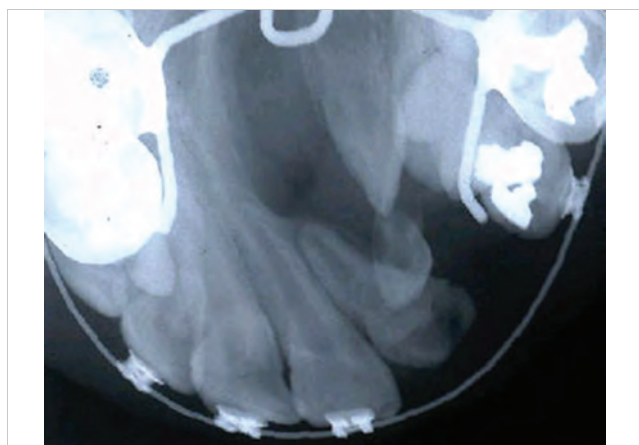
Maxillary occlusal radiograph of left alveolar bone defect.
